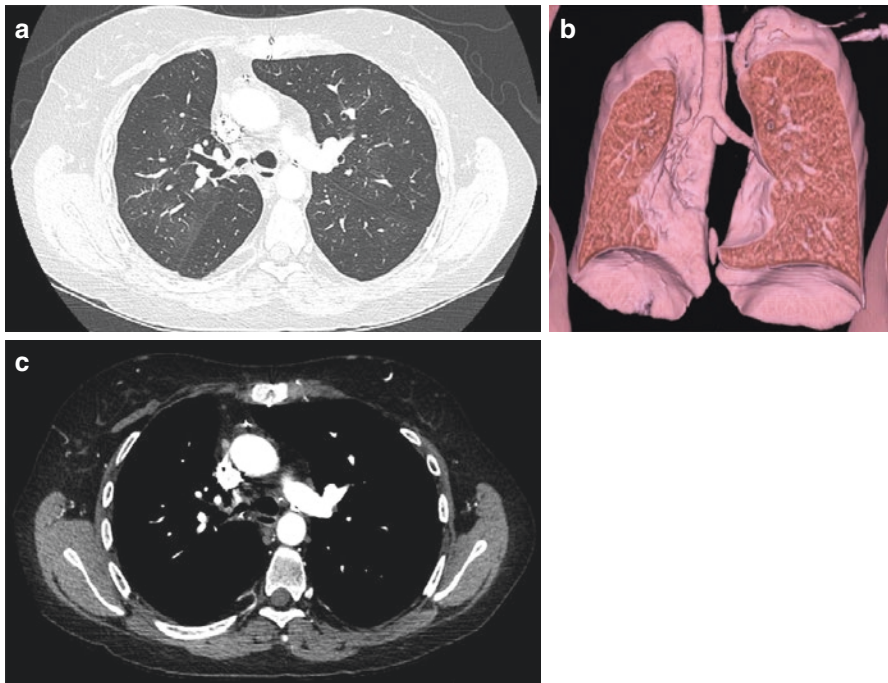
(a–c) A 31-year-old female status post bilateral lung transplant with severe stenosis of the right mainstem bronchus near the site of surgical anastomosis as seen on axial CT (a, b) and volume-rendered (c) images
